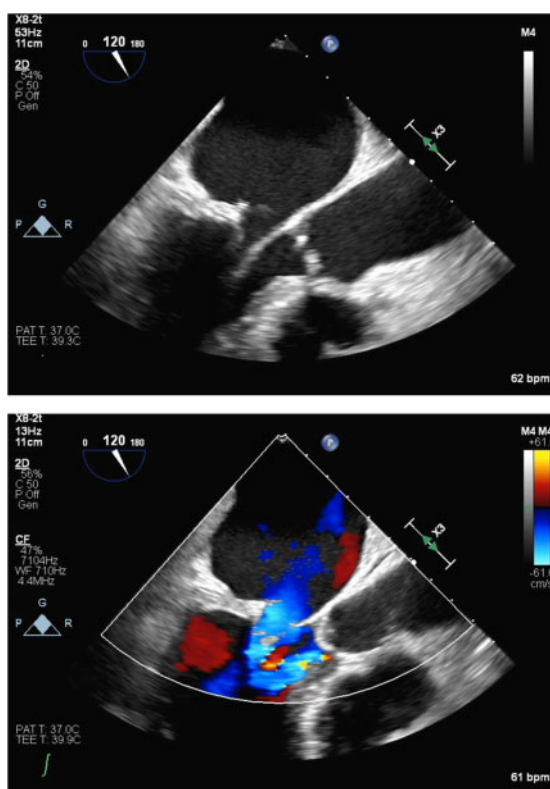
Pre-MitraClip transoesophageal echocardiographic images demonstrated significant systolic anterior motion of the anterior mitral leaflet with the detachment from the posterior mitral leaflet in mid-to-late systole (A) and severe mitral regurgitation (B). Three-dimensional mitral valve viewed from the left atrium (C) and left ventricle (D) in late systole showing that the medial portion of the valve was severely affected (arrowheads). A continuous wave Doppler trace through the left ventricular outflow tract showing the peak velocity of left ventricular outflow tract of 5.4 m/s (E). A continuous wave Doppler trace through the mitral valve showing the transmitral pressure gradient of 5.0 mmHg (F).
